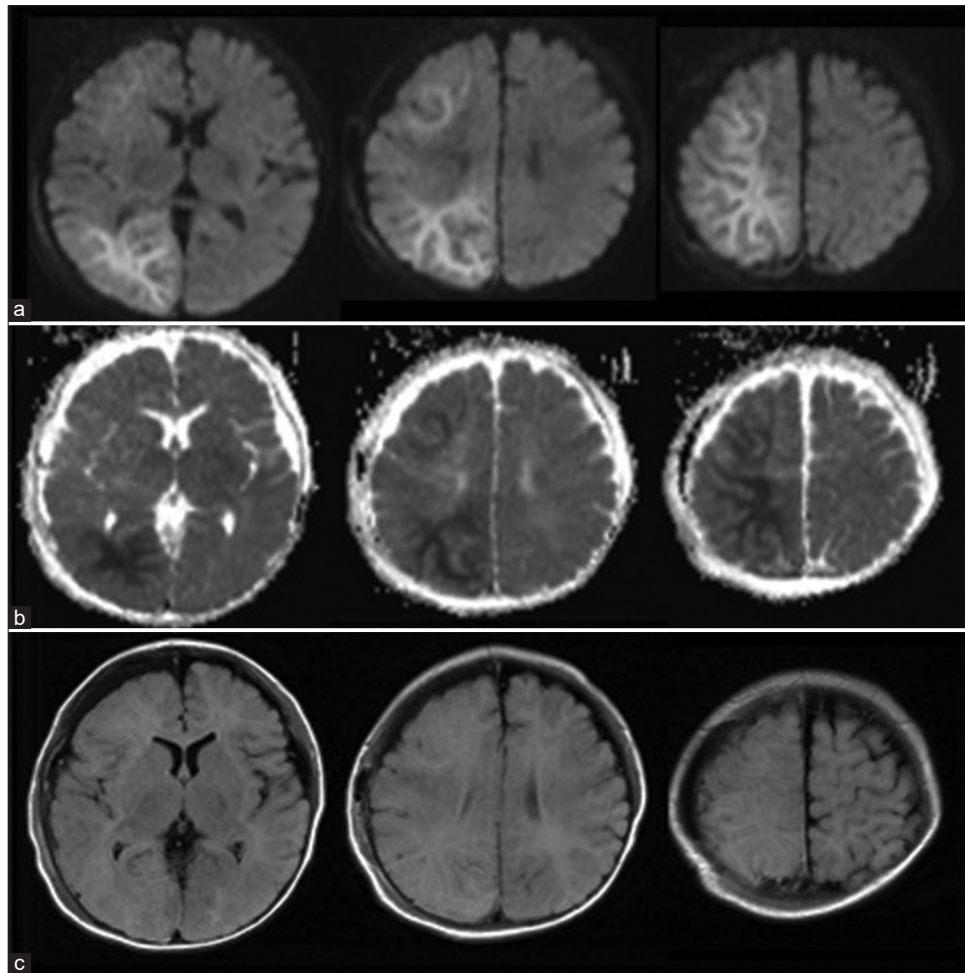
Magnetic resonance images on day 3 revealed the bright tree appearance on the right frontal and parietal lobes at diffusion-weighted images (DWI). That lesion demonstrated low intensity at the apparent diffusion coefficient map image and iso-intensity at the fluid-attenuated inversion recovery (FLAIR) image. (a) DWI. (b) Apparent diffusion coefficient map image. (c) FLAIR image.
